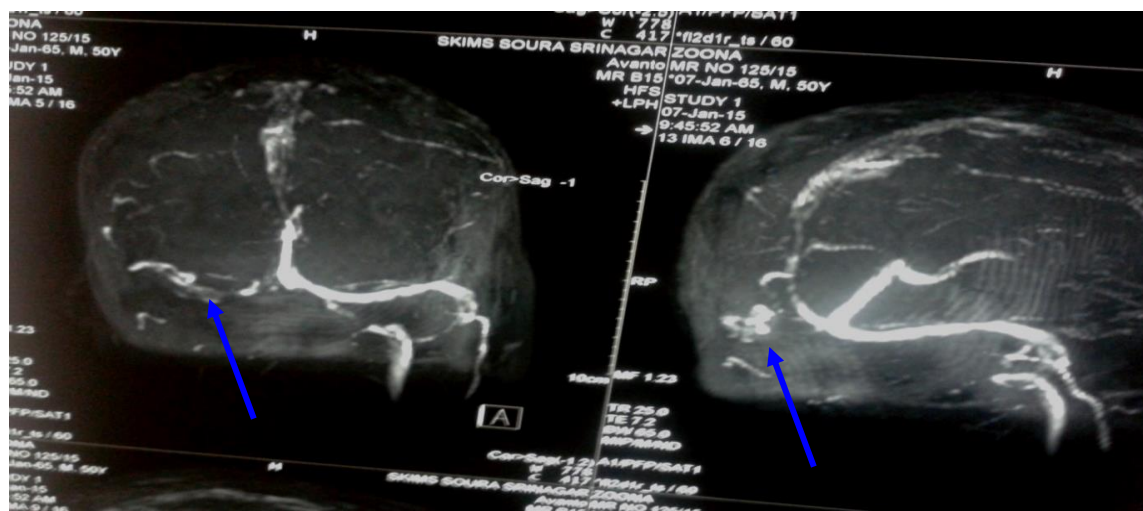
(b): MRI brain showing Infarct and lateral sinus thrombosis
